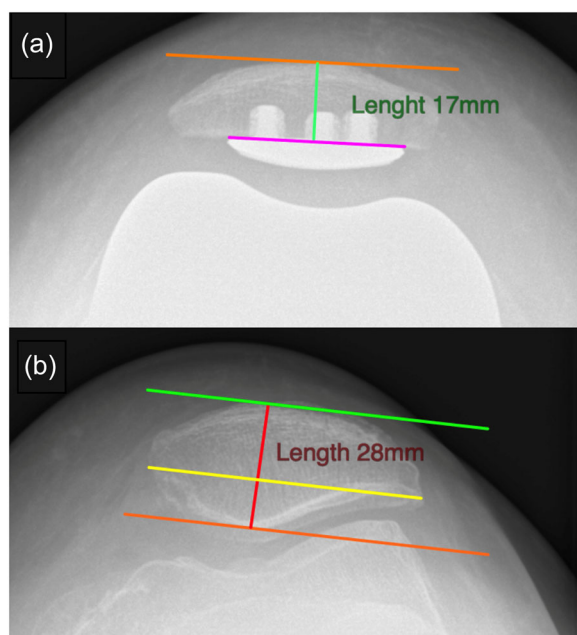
The image shows the methodology for assessing patellar measurements with the self-caliper software. (a) Residual bone thickness (green line) is calculated from the mid-base of the patellar button (magenta line) to the opposite cortex (orange line) in the axial view X-ray. (b) Preoperative full patellar thickness (red line) is measured from the innermost point to the opposite cortex (orange line), perpendicular to the patellar virtual resection line (yellow line) in the axial view X-ray.
